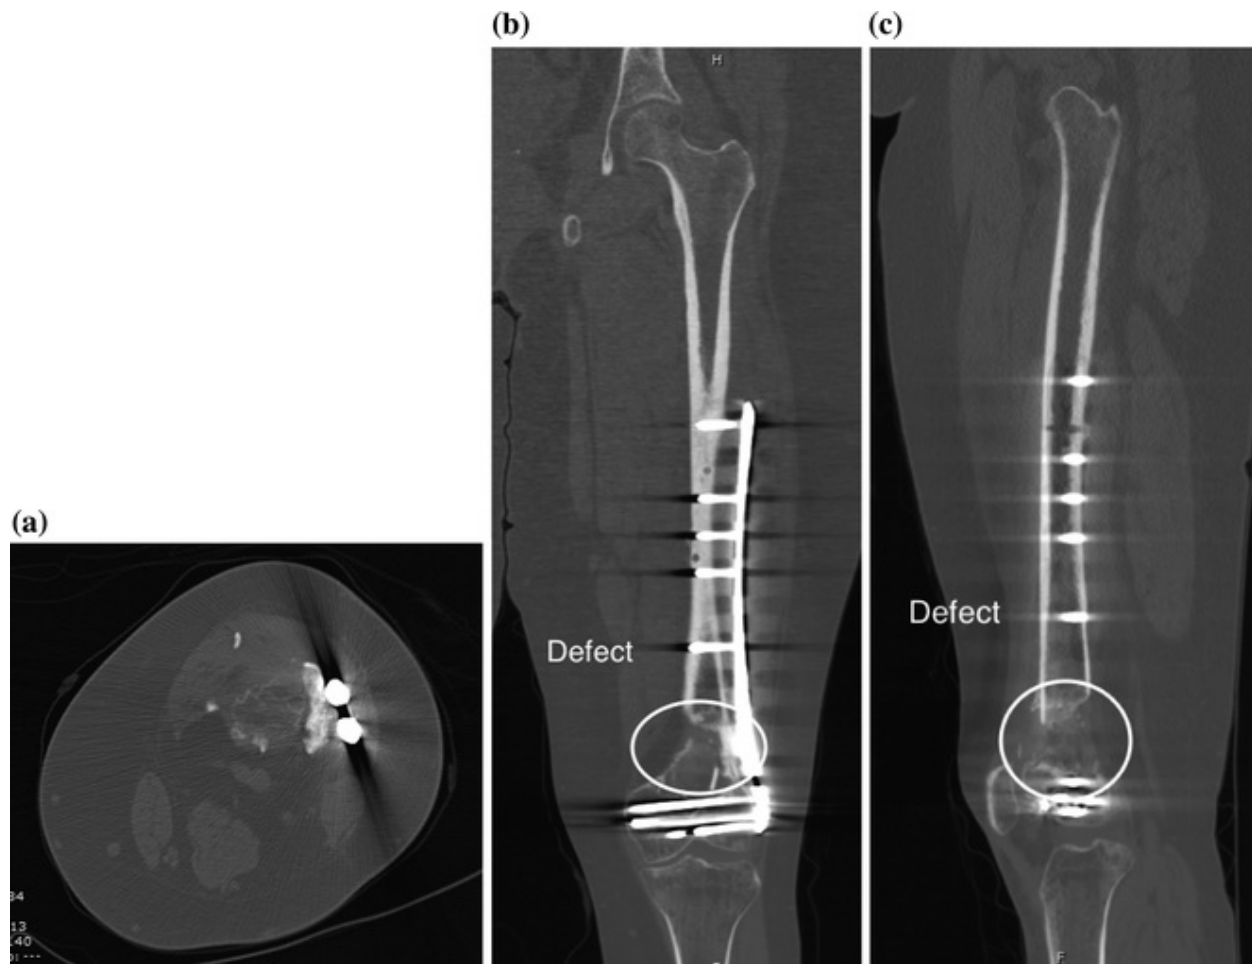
Computed tomography scan images: a axial image shows the lateral bridging but the central nonunion; b coronal image shows the defect centrally but the healed lateral cortex; c sagittal image shows the lack of bridging bone anterior or posterior with central defect
